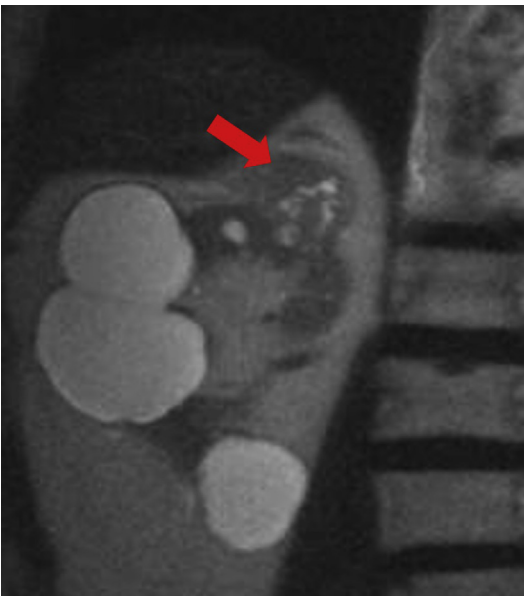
A T2-weighted image depicts mild hyperintensity and heterogeneity within a ccRCC (arrow). Additional homogeneous T2 hyperintense simple cysts are also seen within the right kidney.
